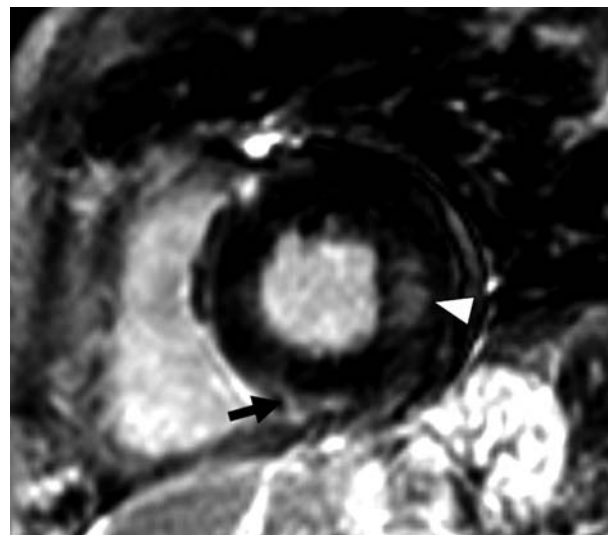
Cardiac magnetic resonance image showing delayed hyperenhancement of the basal inferoseptum (black arrow) and the basal inferolateral wall (white arrowhead)
